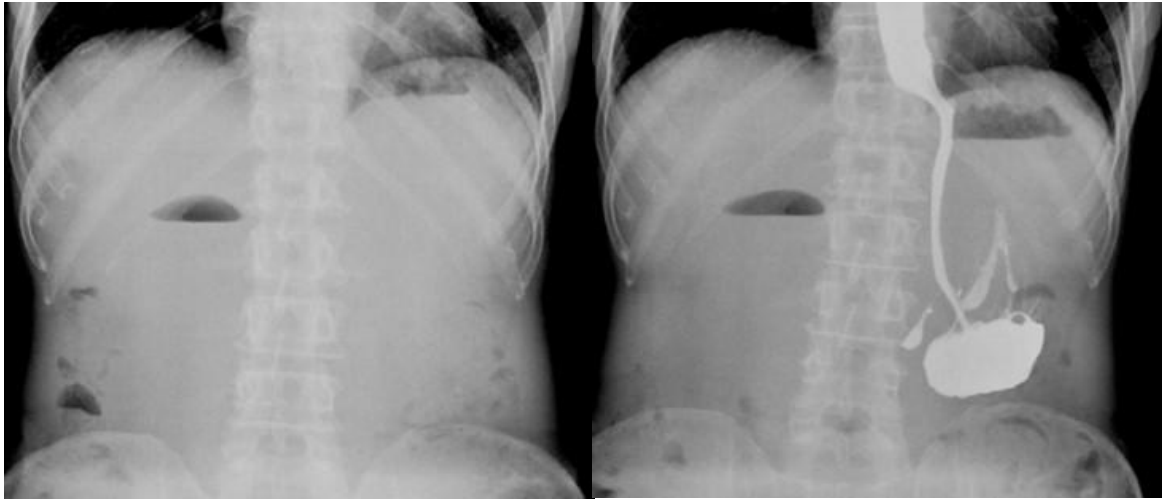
(A, B). Abdominal plain (A) and contrast (B) erect radiograph demonstrates air fluid levels in left & right hypochondrium(Double bubble sign) suggestive of duodenal obstruction.
